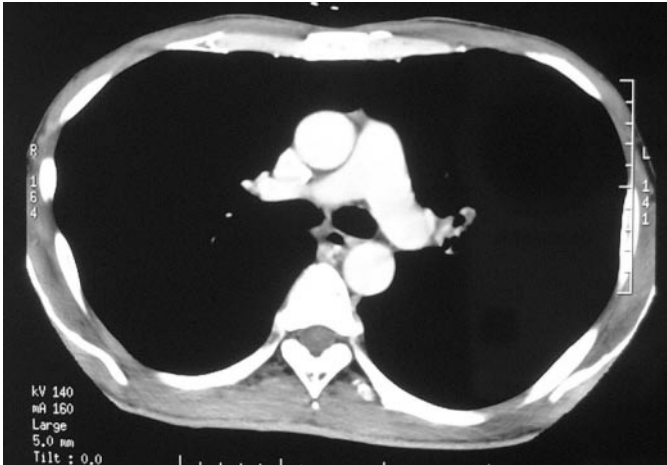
Computed tomography after the first treatment showing decreased size of the left hilar mass (December 2002).
